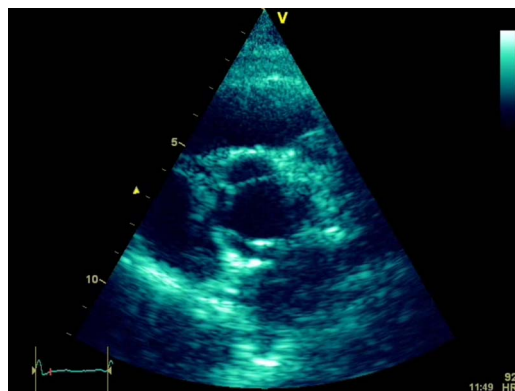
Echocardiographic image, left parasternal short-axis view at aortic valve level showing quadricuspid aortic valve.
